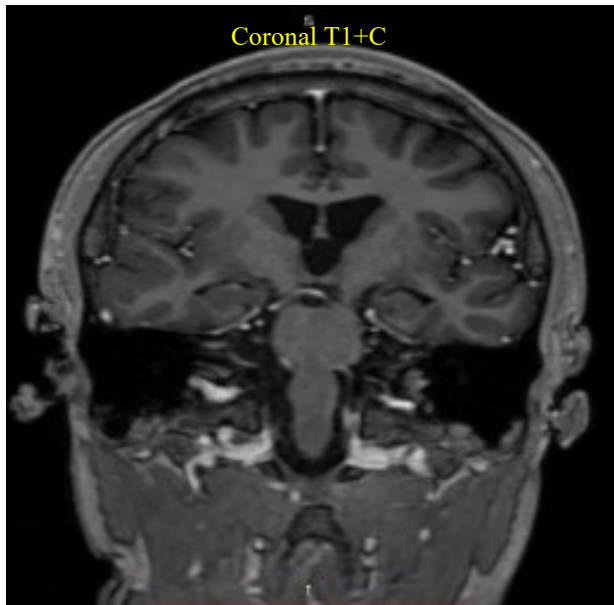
Head MRI Results with Contrast
